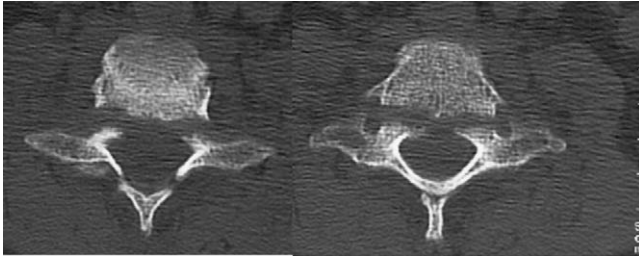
High-resolution computed tomography of the cervical spine showing disruption of the neural arch of the C6 vertebrae in addition to the deformities seen in the plain film and suggesting acute trauma as a cause of the anomalies by virtue of the sharp edges of the fracture and disrupted trabeculae.
